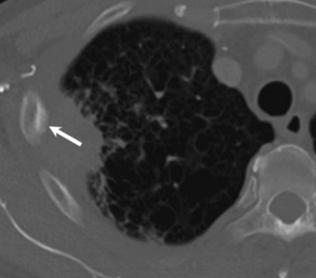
A 65-year-old man with intractable right chest pain. Contrast-enhanced axial CT images show a peripherally located right upper lobe malignant mass touching the intercostal space and associated with focal pleural thickening, periosteal reaction (arrow) in the adjacent rib but without any destruction. CT findings were equivocal for chest wall invasion but the presence of pain helped in concluding the chest wall invasion
